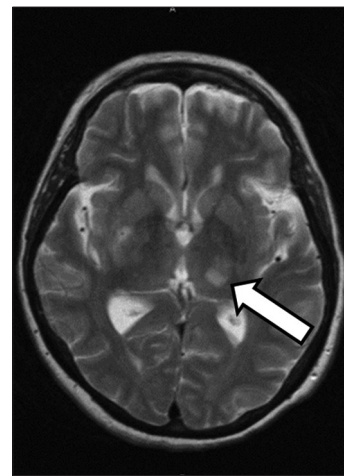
T2 brain magnetic resonance imaging showing left thalamic infarct (arrow) after the second stroke in patient 2.
